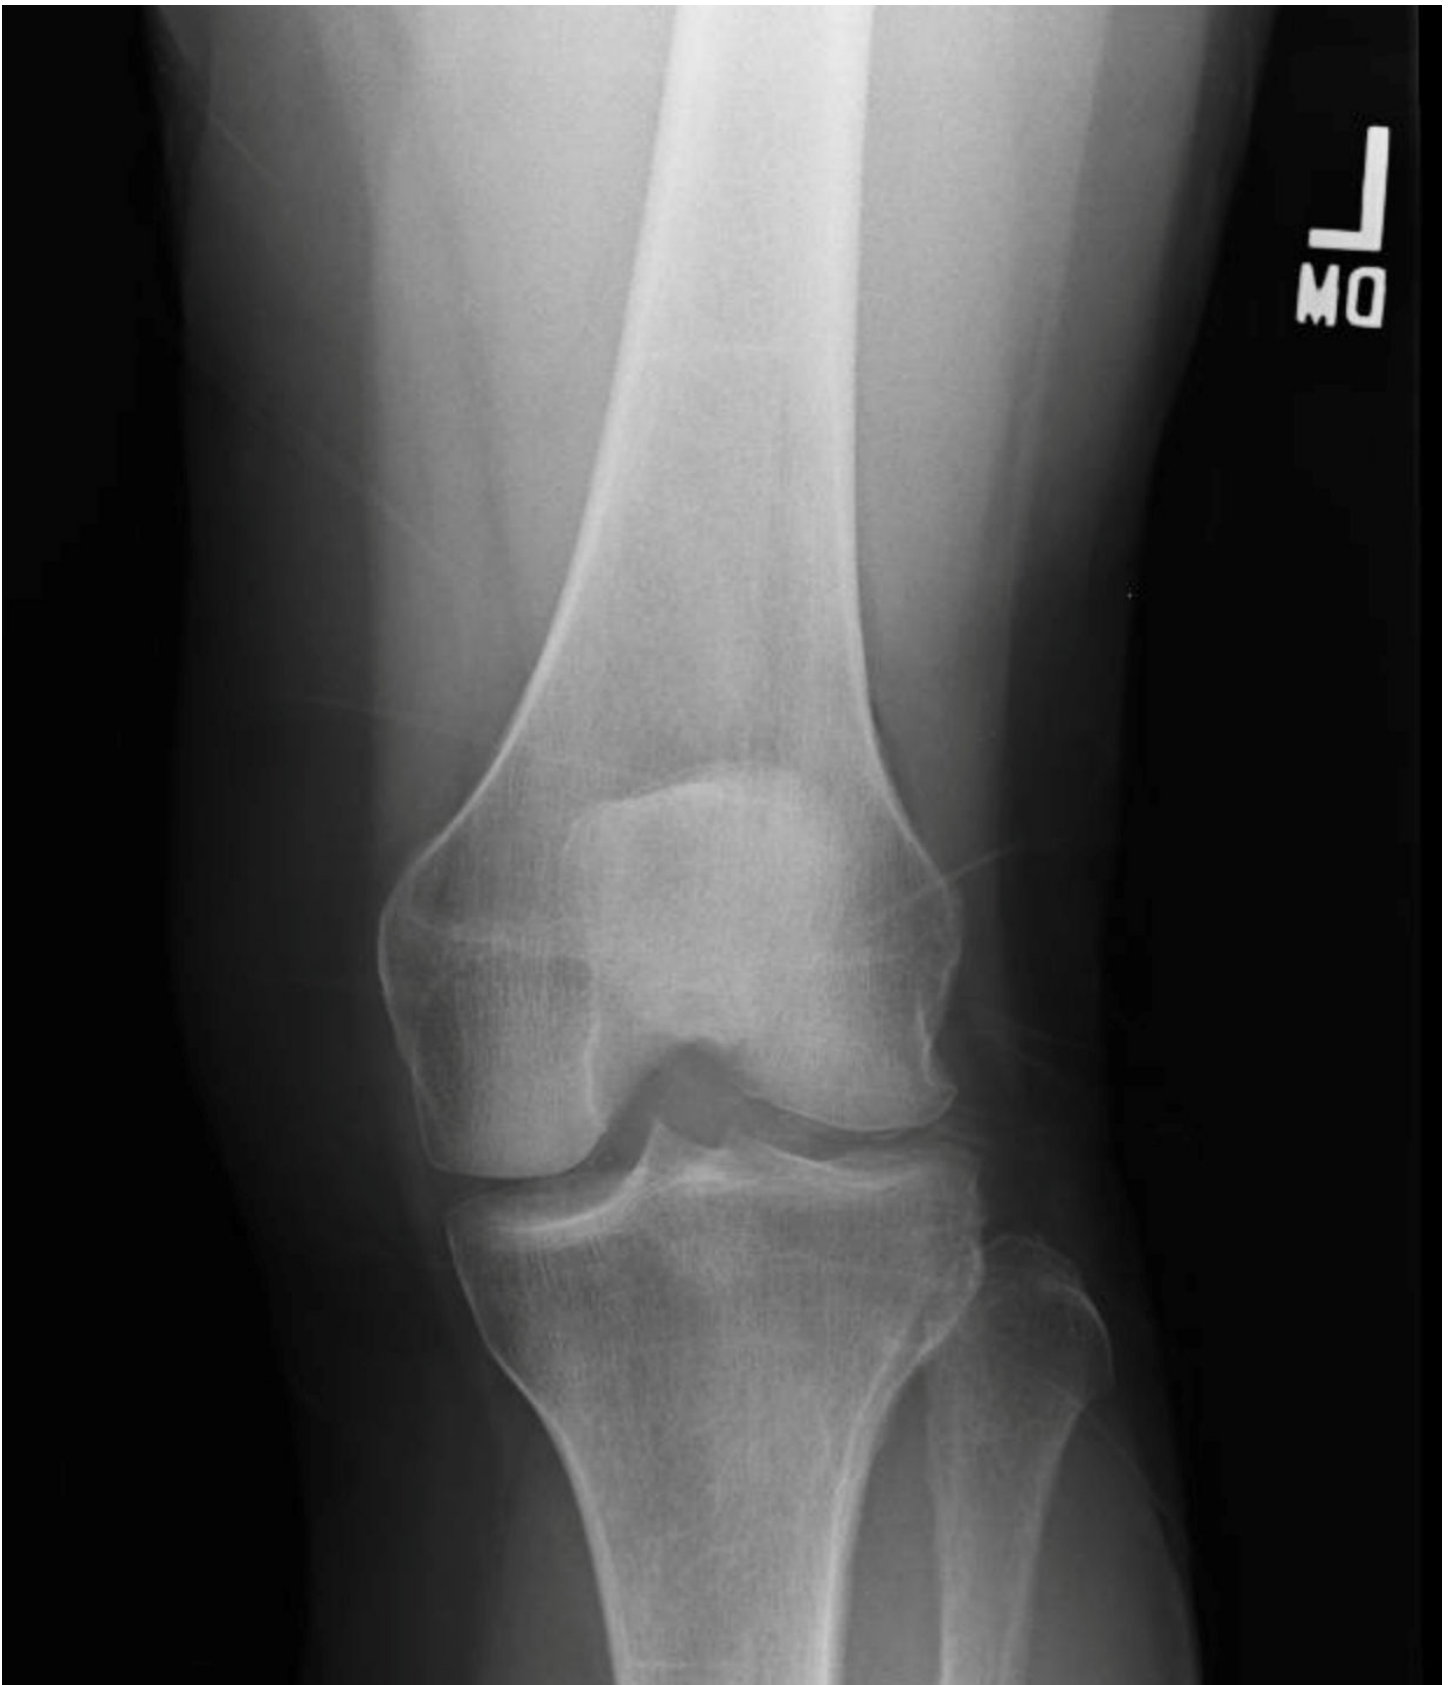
Radiograph of treated adult hypophosphatasia: linear sclerosis in remodeling distal femur and proximal tibia, osteophytes mid-proximal tibia, and chondrocalcinosis medial lateral compartment
